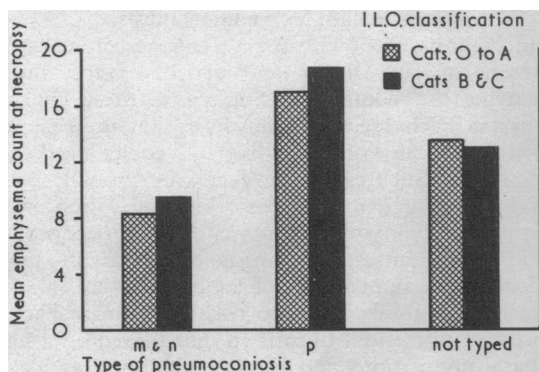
Mean emphysema count by type of opacity on final x-ray film.
